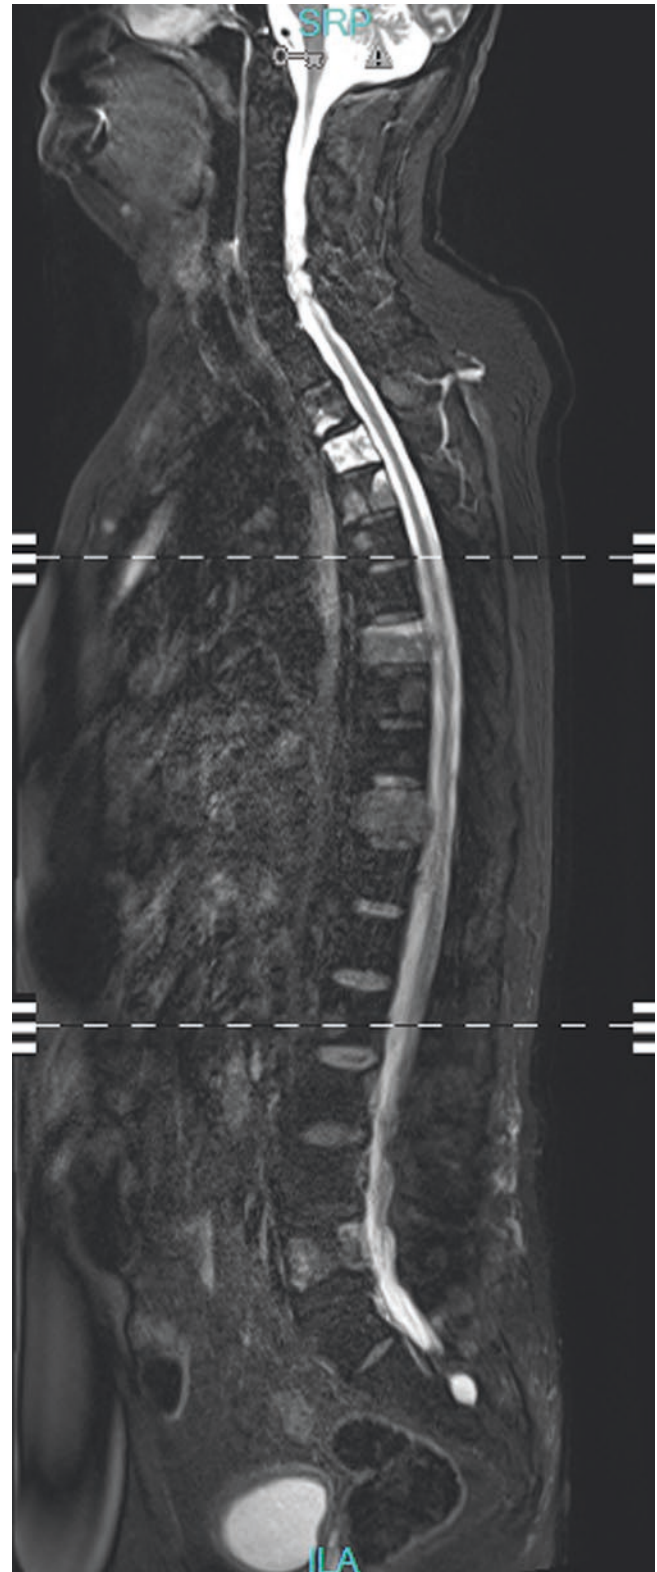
Sagittal MRI of epidural metastases
